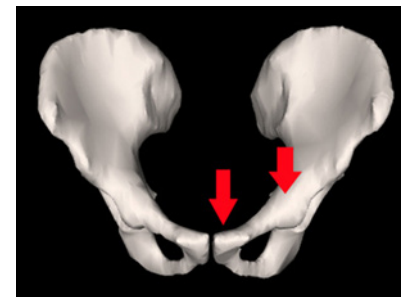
Visible Human pelvis in the coronal orientation. Red arrows mark the sites of the lesions on coronal MRI scans.
